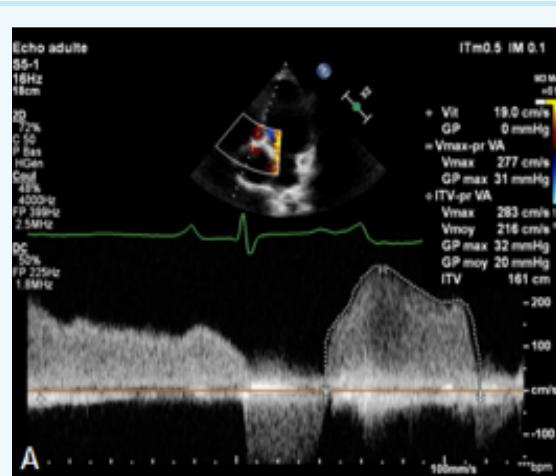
Doppler echocardiography of the tricuspid valve showing markedly high TV gradient peak velocity.
